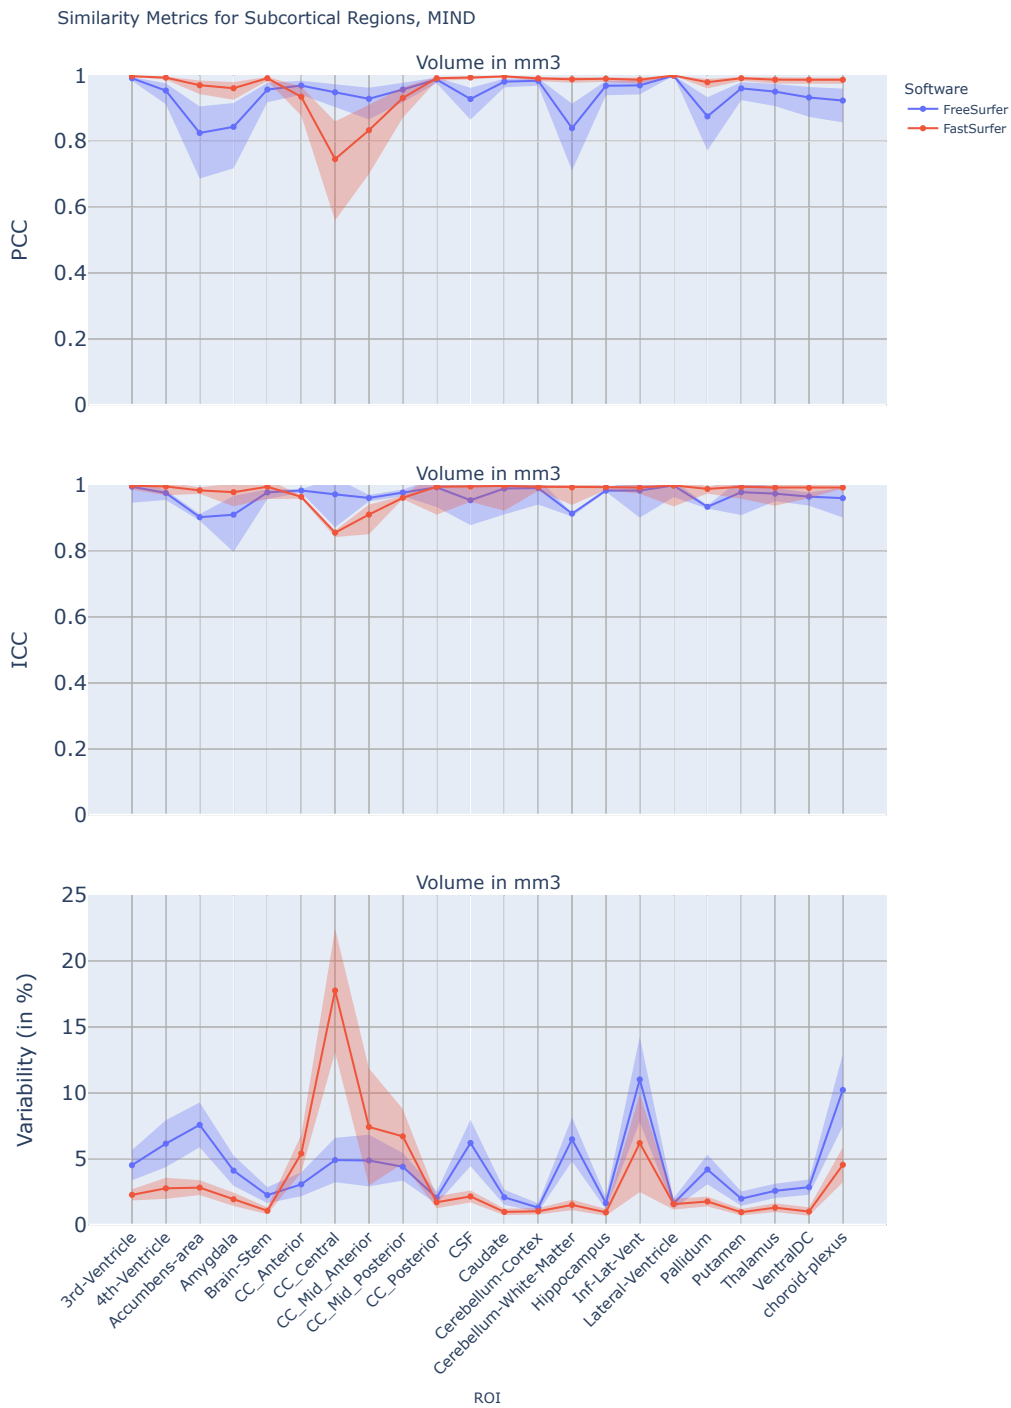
The test-retest reliability, quantified by the PCC, ICC and TRV, between the first and second MRI scans from the MIND dataset for subcortical volume measurements. The plot at the top shows the PCC, the middle one the ICC and the bottom one the TRV. The metrics were calculated for all non-zero subcortical volumes, using estimates from both the FreeSurfer and FastSurfer software separately. The solid lines represent the calculated values, while the transparent bands indicate the 95% confidence intervals around each estimate. Details on specific values can be found in Tables B.15 and B.16.
